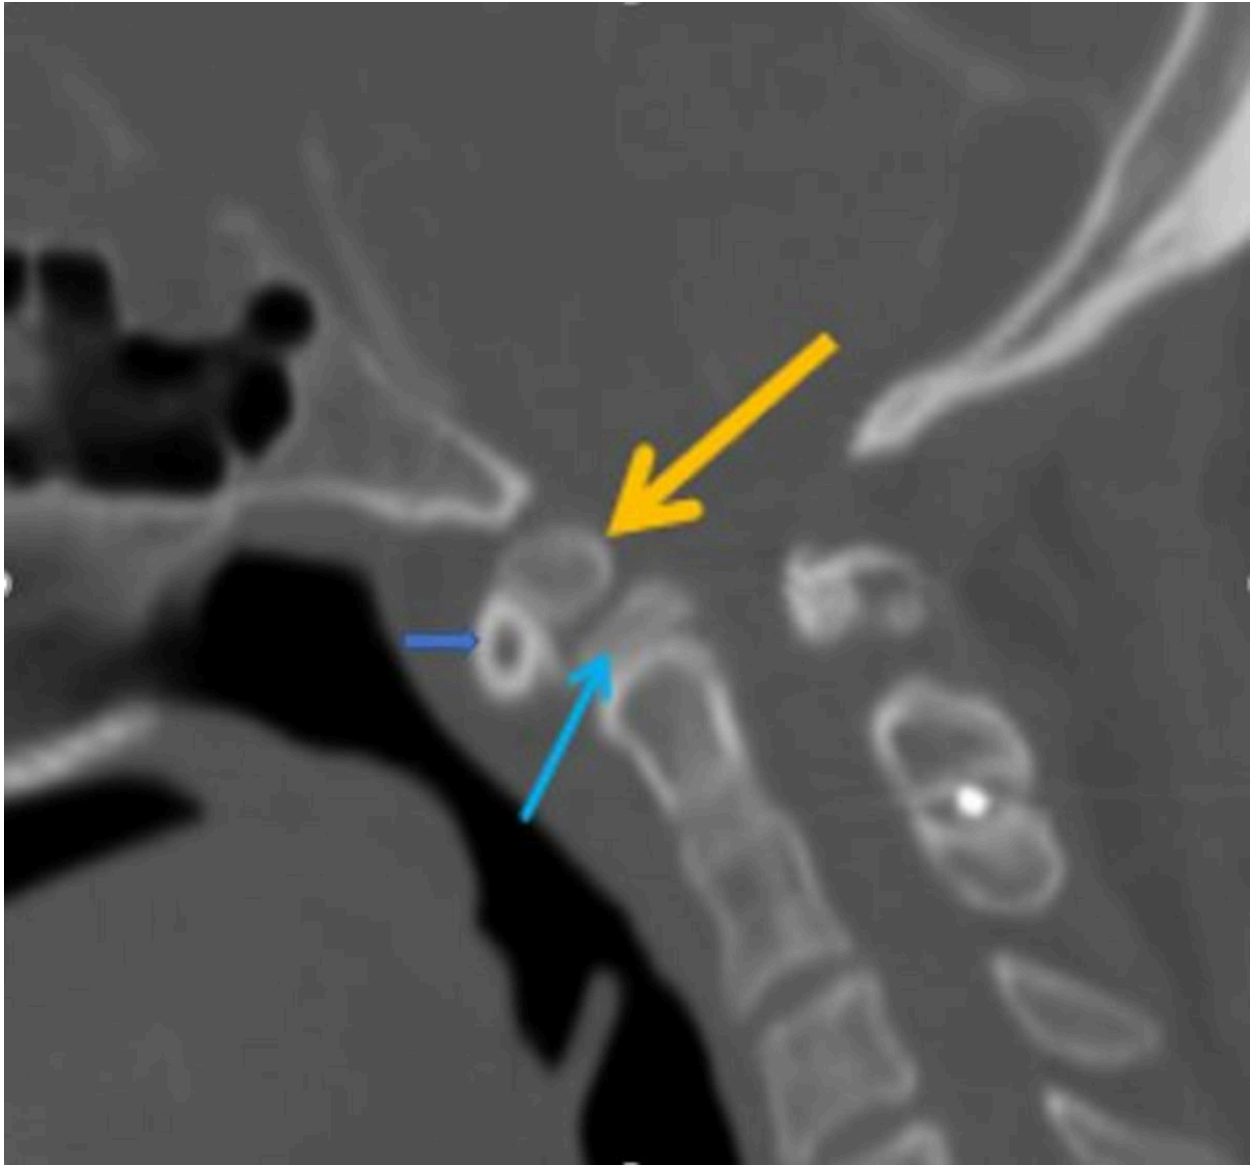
CT sagittal section showing os odontoideum(yellow) with ossiculum terminale(blue)
